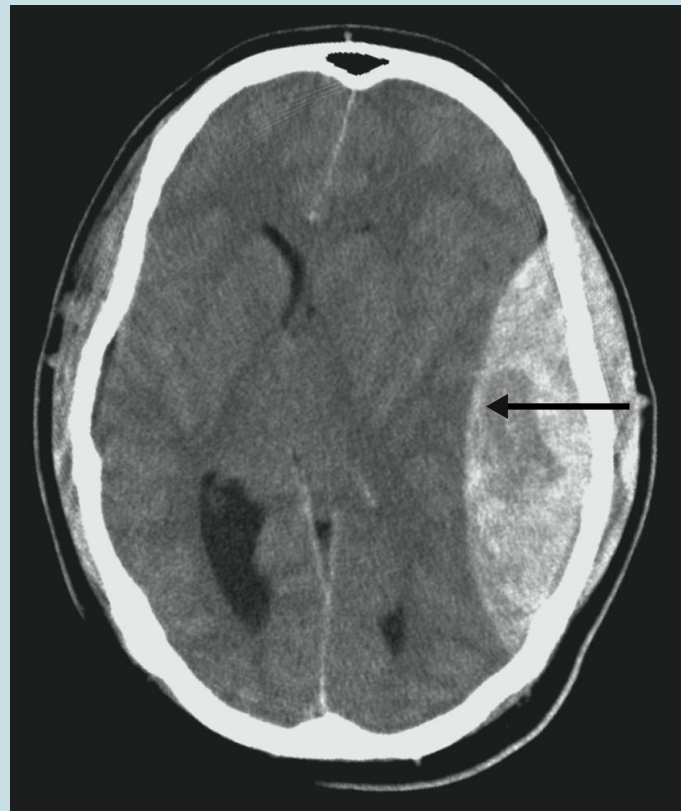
CT scan of a large, left-side epidural hematoma resulting from a motorcycle crash in which the rider was not wearing a helmet. Arrow shows where blood pooling within the cranium has compressed the brain tissue. Patient’s left side is on the right side of the image. Courtesy of Lee Faucher, M.D., University of Wisconsin SMPH.
